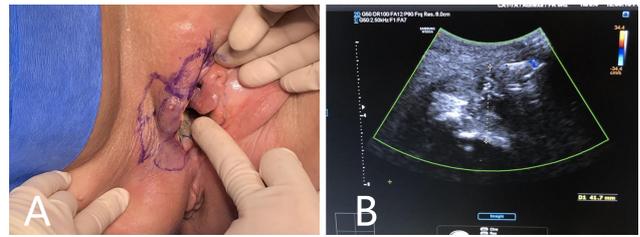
Patient F. (A) Large tumour affecting mostly the right lower vagina and vulva. (B) Patient F: Intra-operative ultrasound on the right vulval lesion.
